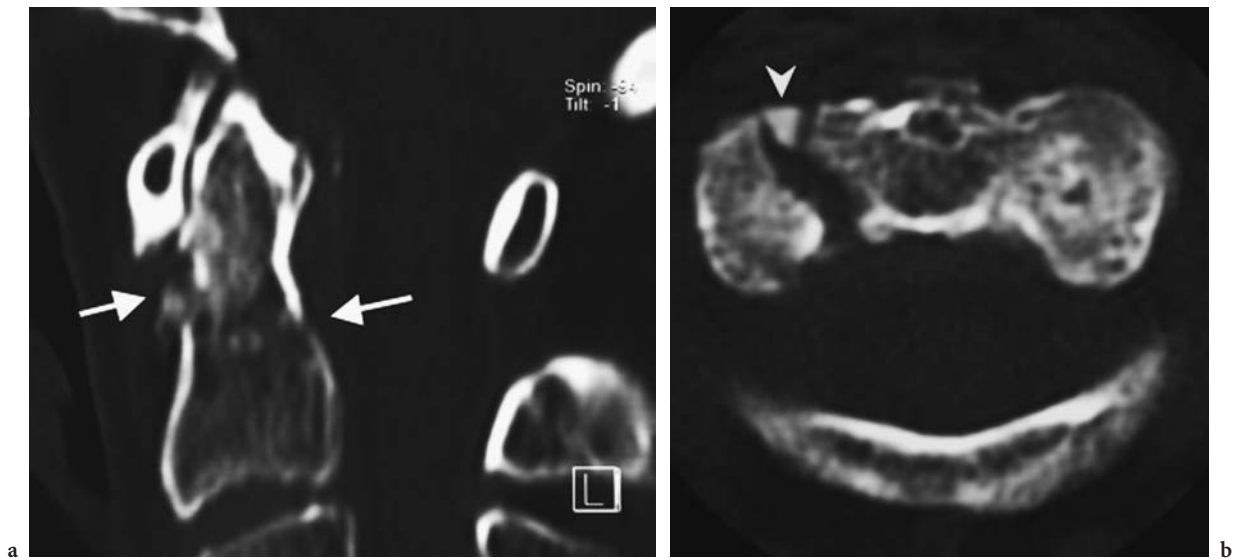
Odontoid fracture: type IIa. a Sagittal CT reformation. b Axial CT image. Fracture at the base of the odontoid process (arrows) with small bony fragments (arrowhead)
